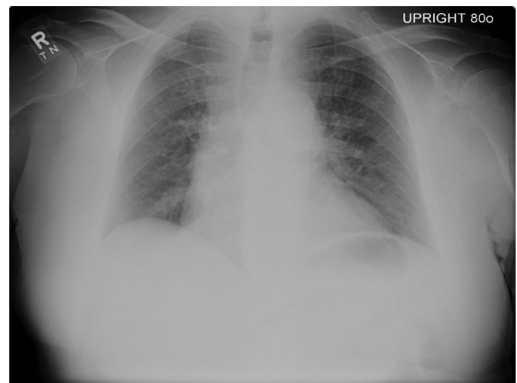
Chest radiograph demonstrating diffuse hazy bilateral nodular infiltrate.
